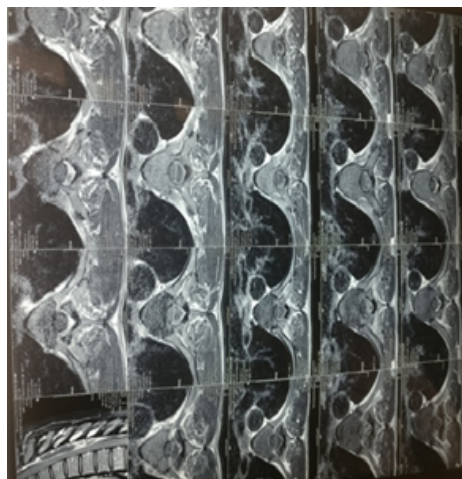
MRI Spine- Coronal section, showing SEA compressing spinal cord.
